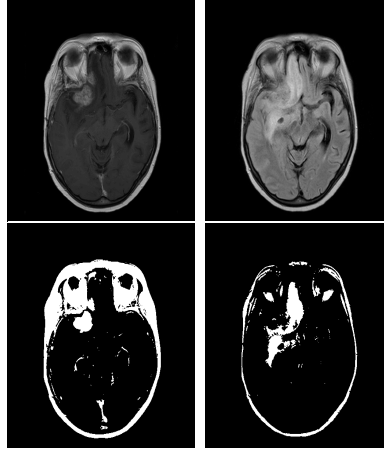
Thresholding effect on one slice. Top row from left to right: T1C, FLAIR. Bottom row from left to right: thresholding results for τ_A (T1C) and τ_B (FLAIR).
